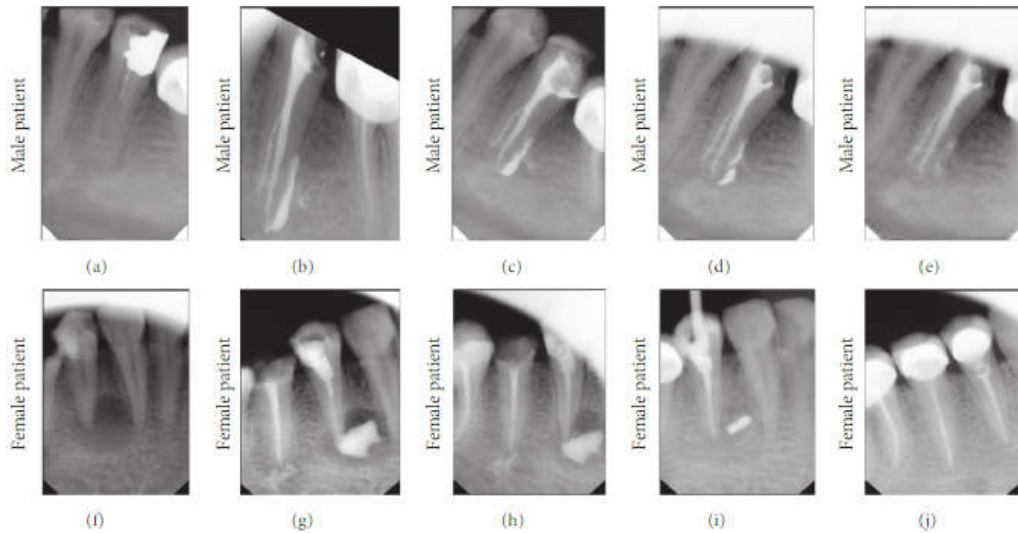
Randomly selected cases to represent the healing pattern of periapical lesions when using calcium hydroxide-iodoform-silicon oil paste
